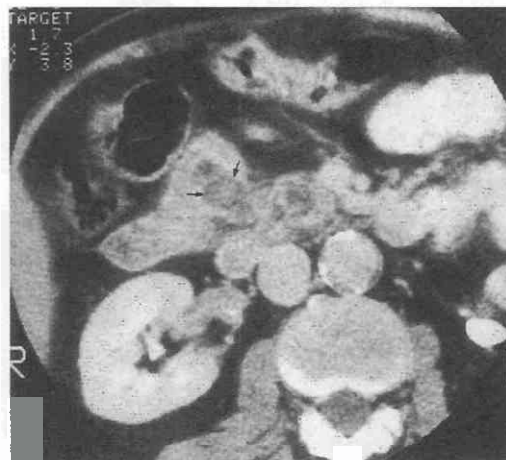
Protrusion of pancreatic carcinoma into distal common duct (arrows) mimics soft tissue density stone. (From Baron RL: Computed tomography of the biliary tree. Radiol Clin North Am 29:1235, 1991.)
